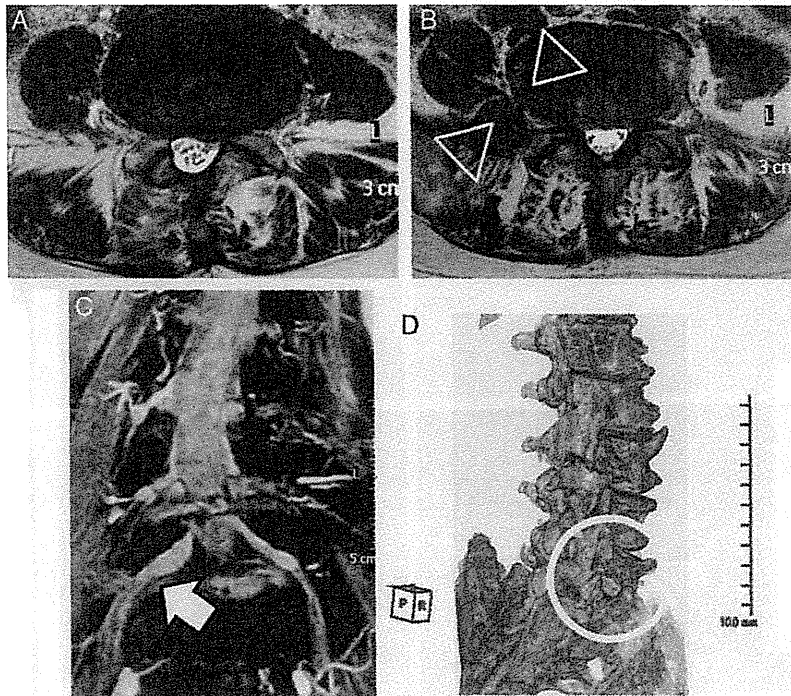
Case 1. Images obtained in a 73-year-old woman who presented with severe right leg pain. A, No residual spinal canal stenosis was found at the L4-5 segment. B, The existence of bony stenosis between the bony spur of L5 vertebral body and the sacral ala (white triangle) was suspected. C, On the multiplanar reformat view obtained from 3-dimensional-magnetic resonance imaging studies, extraforaminal entrapment of the fifth lumbar spinal nerve was seen between the sacral ala and osteophyte formation at the L5-S1 segment (white arrow). Swelling of the spinal nerve root and ganglion was also observed. D, 3-dimensional-computed tomography image taken after surgery demonstrated adequate bony decompression without violation of the L5-S1 facet joint.
